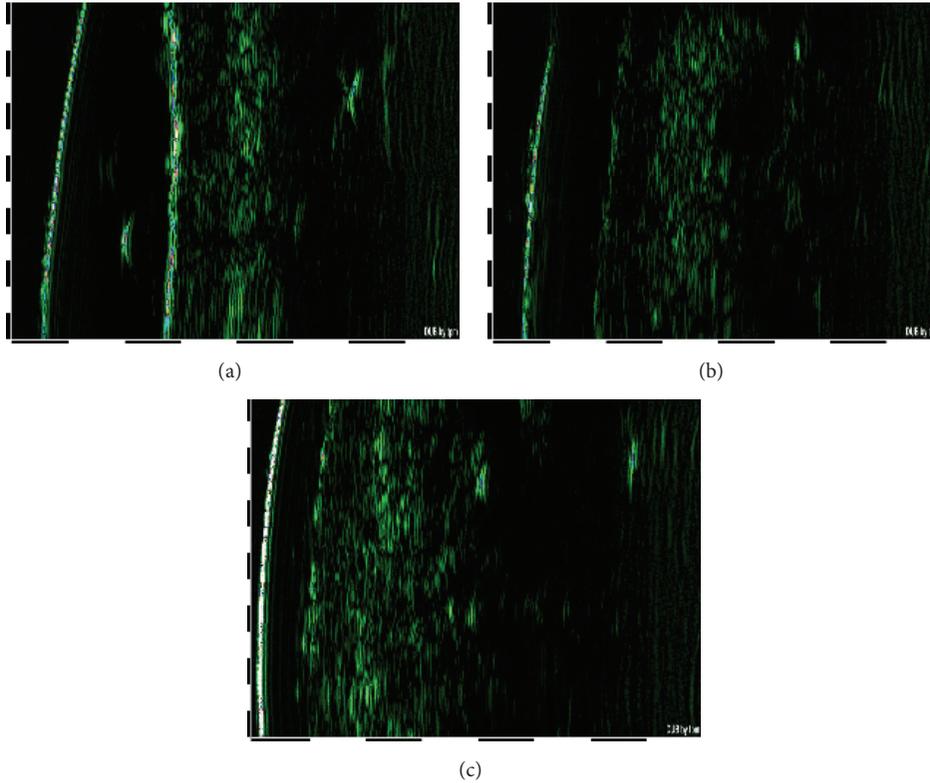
Digital images of facial skin ultrasound examinations (patient number 23, e.g.), made 2 months before the beginning of the trial (a), at the day of the trial beginning (b), and immediately after the trial cessation (c).
